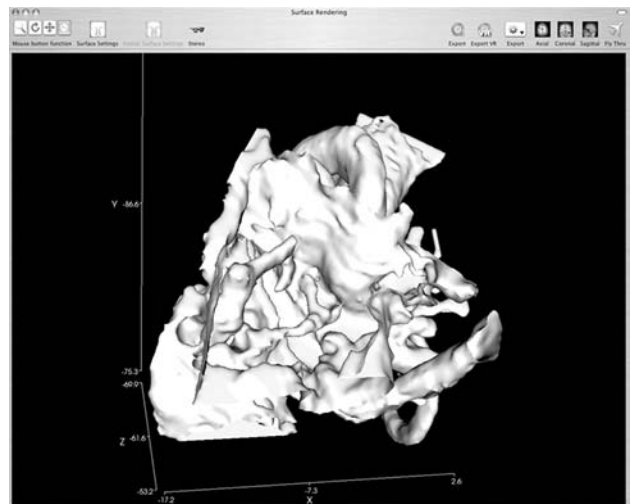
Three-dimensional surface model of the middle ear cavity of a temporal bone by dint of a DICOM dataset of a 64-multislice Computer Tomography (CT), an adapted version of the open-source program OsiriX, and by manual segmentation
